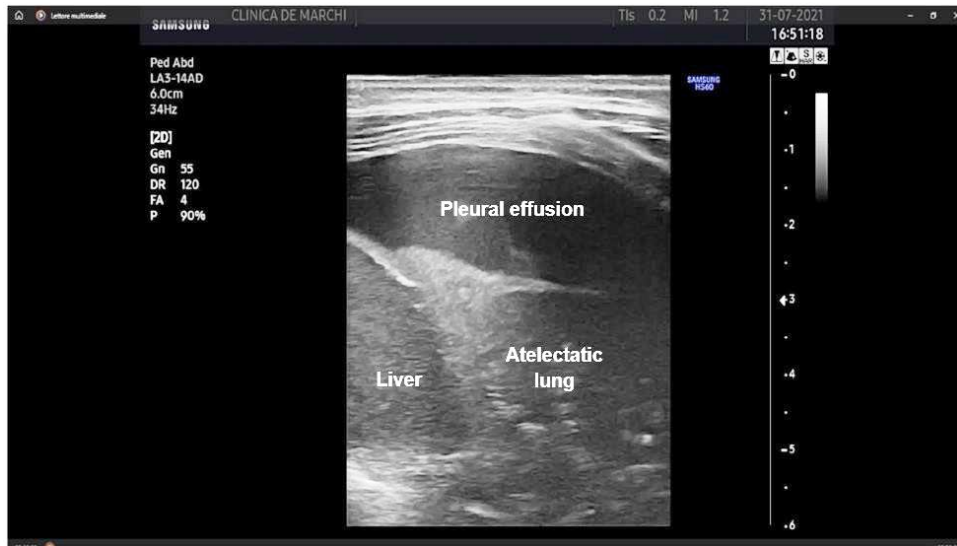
B-mode lung ultrasound with pleural effusion. (adapted from Chidini et al, 2024)
